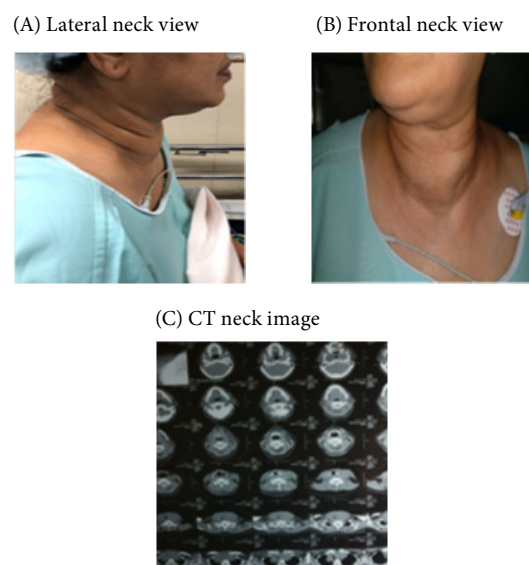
(A) Lateral and (B) frontal clinical photographs showing anterior neck swelling in case 3. (C) computed tomography (CT) image demonstrating diffuse enlargement of both thyroid lobes with marked tracheal deviation and near-complete compression.
